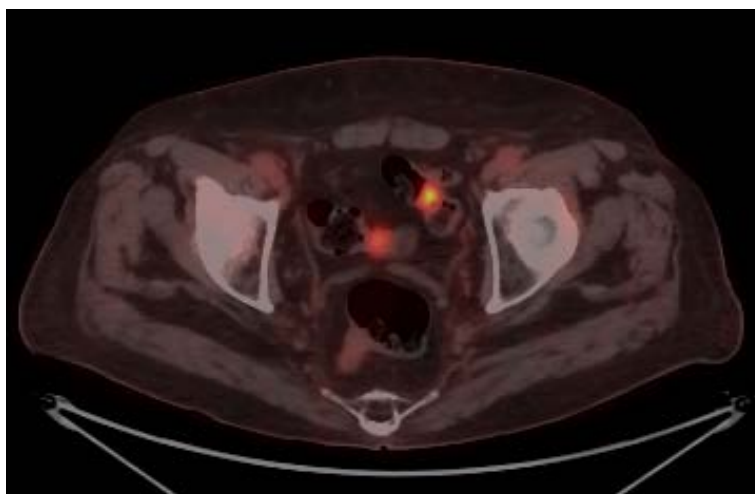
Oncological PET-CT, Increased FDG uptake with polypoid appearance was observed at the sigmoid colon level.
